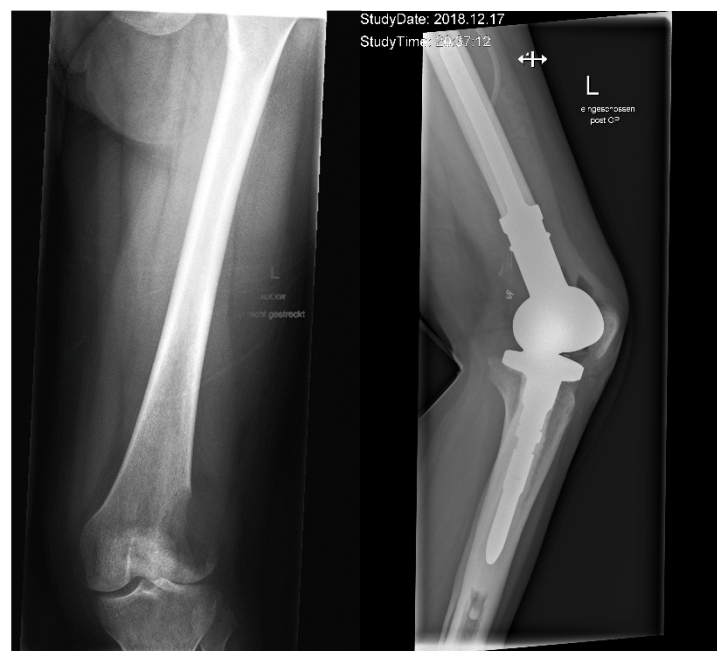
Left side: Osteolytic GCT lesion located at the distal left femur. Right side: Implanted endoprosthesis. (Radiography of one of our GCT patients.)
